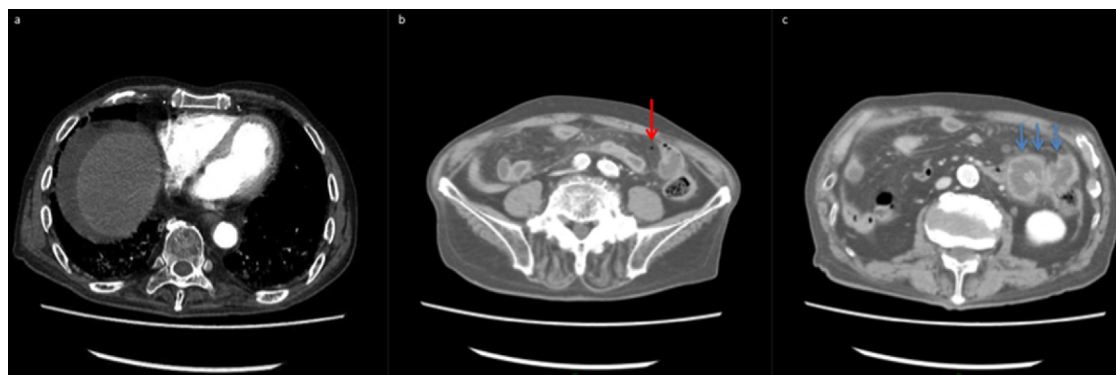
A contrast CT of the abdomen showing ascites (a), free air (b; red arrow), and irregular thickness of the small intestinal walls (c; blue arrows).
